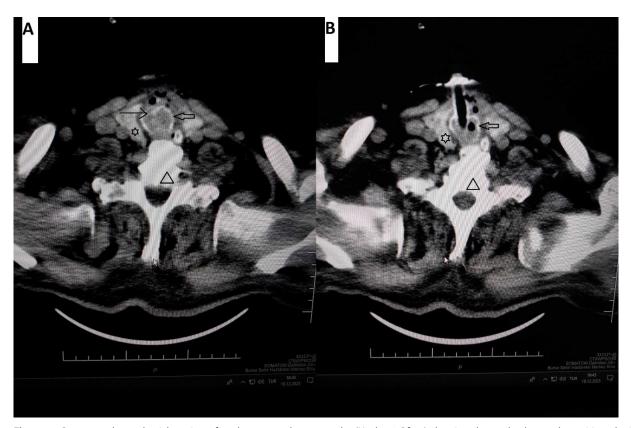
Contrast-enhanced axial section of neck computed tomography (Neck 5.0 Bf 37) showing the tracheal cannula positioned within the trachea. Line arrow: soft tissue mass in the anterior part of tracheal lumen. Hollow arrow: third tracheal ring. Star: right lobe of thyroid gland. Triangle: body of seventh Cervical vertebra.
